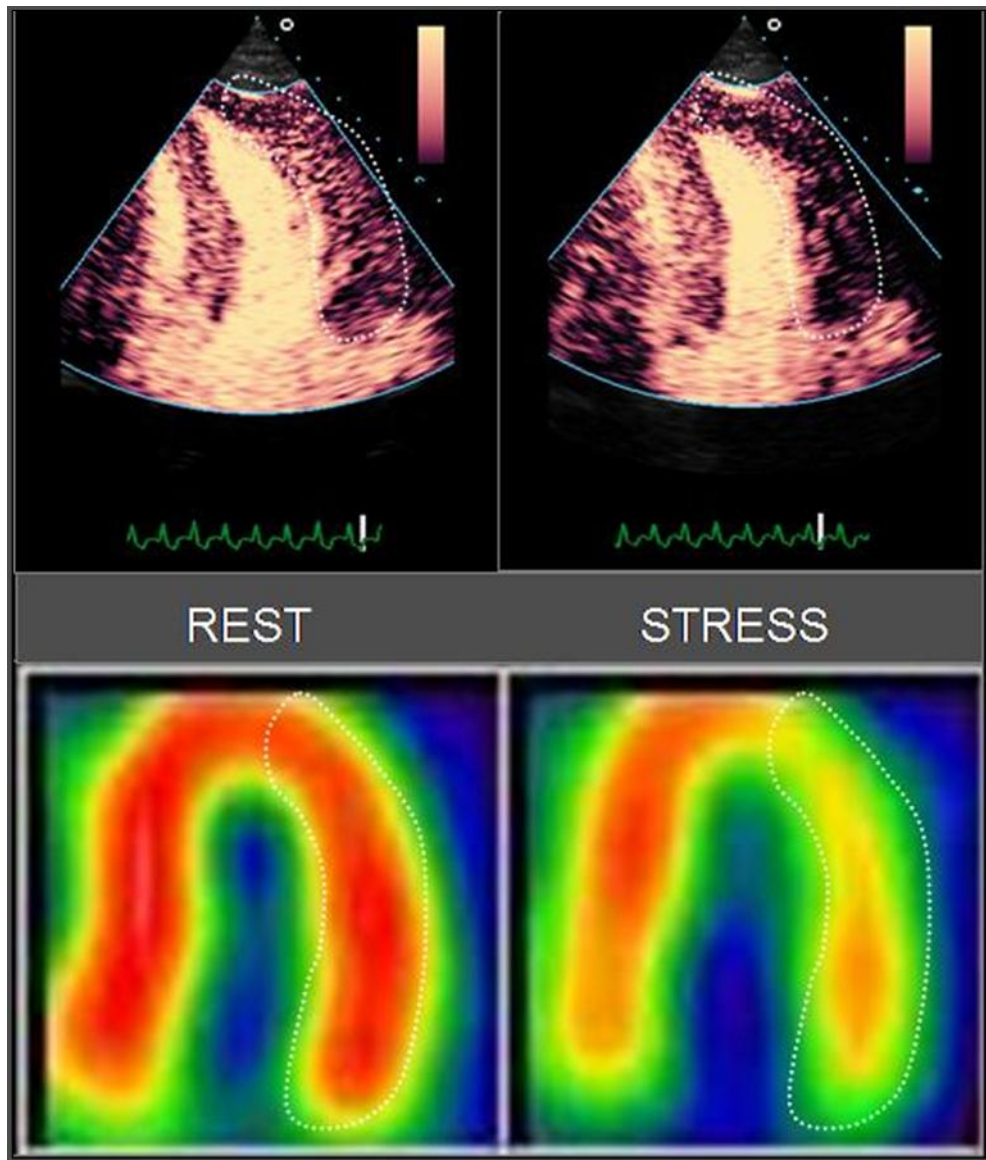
Anterior ischemia seen as a perfusion defect during adenosine stress in RTP (top) and SPECT (bottom).
